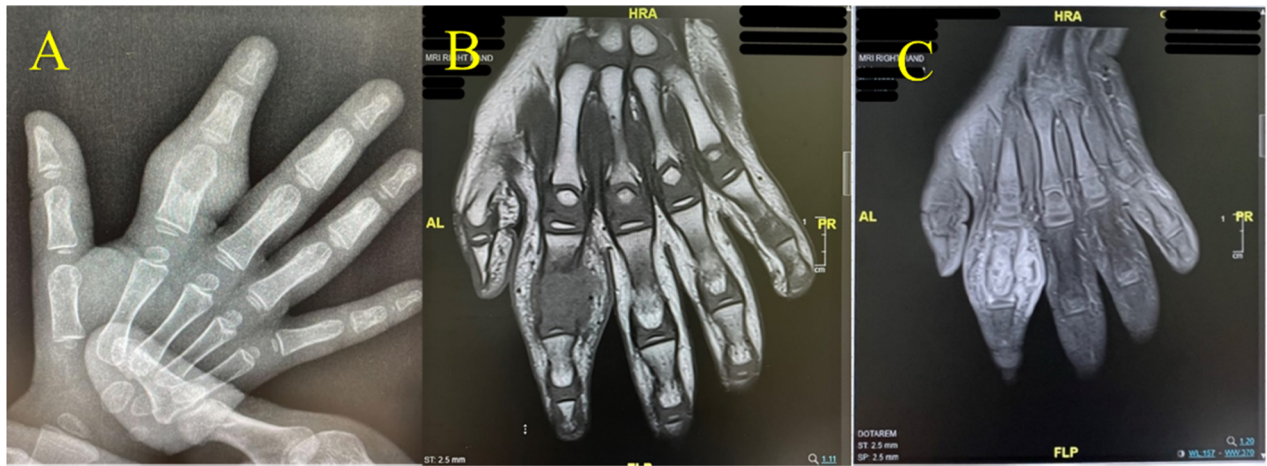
A: X-ray of the right hand showing an expansile lytic bone lesion in the proximal phalanx of the index finger. B: T1-weighted MRI (T1WI) showing destructive hypo-intense bone lesion with mild extraosseous involvement. C: Postcontrast T1WI MRI revealing a moderately enhancing lesion within the bone and surrounding soft tissue.
